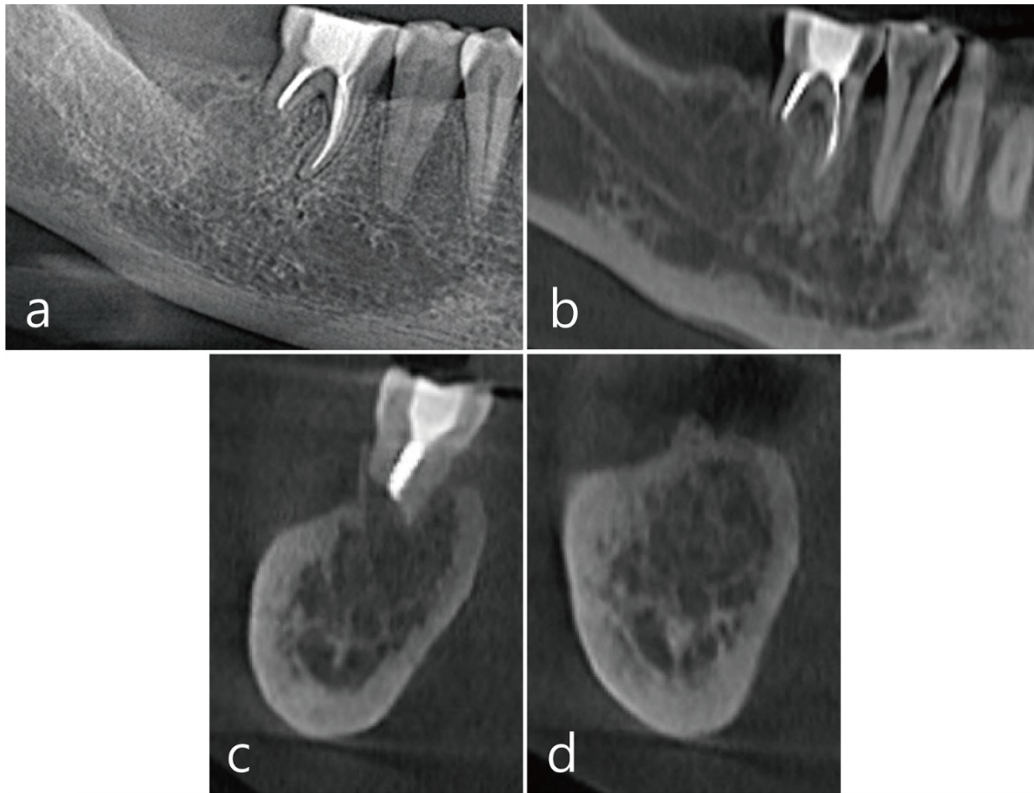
Radiographic findings one year after FCOD excision with apicoectomy. (a) In the panoramic radiograph, radiolucent trabecular bone was observed around the previous DCOD site; (b) In the sagittal image of CBCT, an osteoporotic site was present at the previous FCOD site; (c) Coronal image of CBCT scanned at the distal root of #30 tooth. An osteoporotic marrow was observed at the previous FCOD site; (d) An osteoporotic area was also observed at the mesial site of #31 tooth extraction socket.
